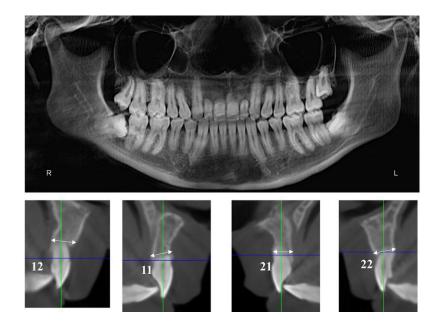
Patient 2. Panoramic radiograph generated from the CBCT and CBCT images of maxillary incisors at 5 years of follow-up for stability and root size of incisors control. 12, ight lateral incisor; 11, right central incisor; 21, left lateral incisor; 22, left central inciso
